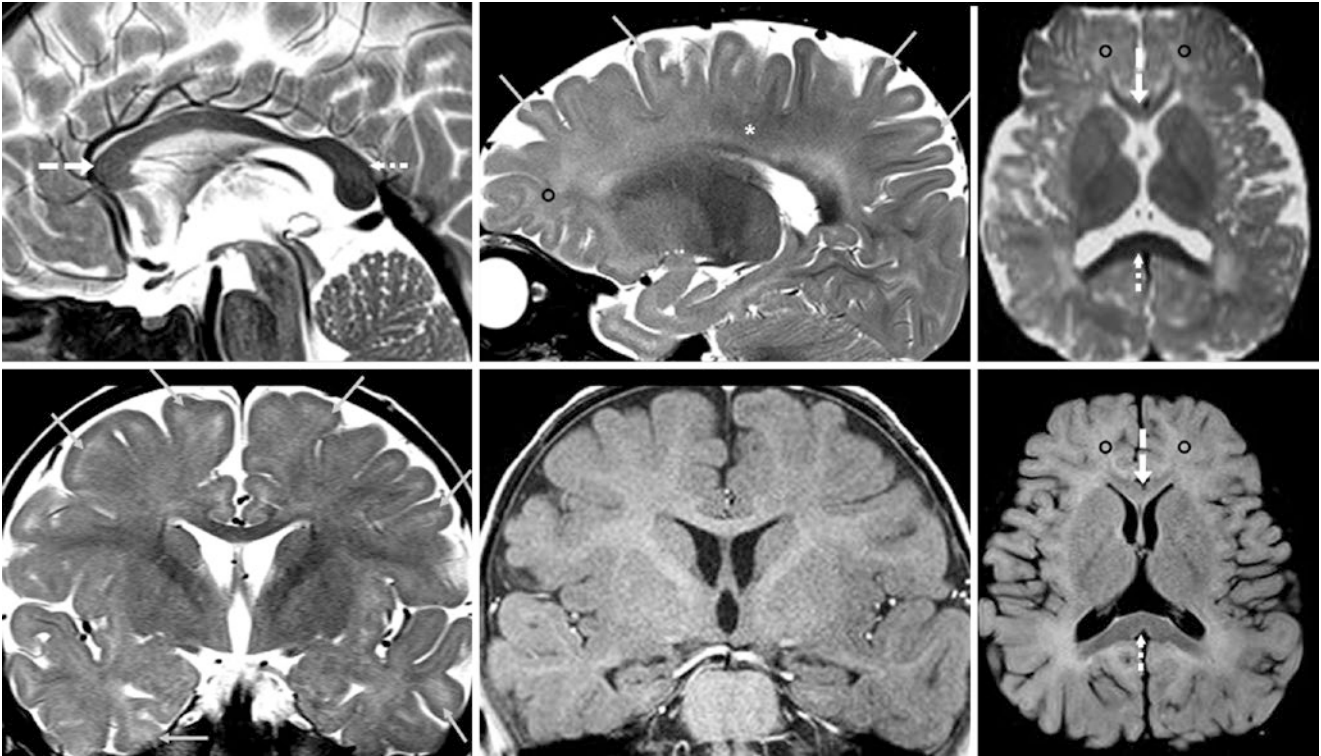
A 9.75-month-old with growth hormone deficit had a normal pituitary MRI at 3T. A sagittal SE T2WI (*top left*) shows a mature CS (*dotted arrow*); the CG (*dashed arrow*) is slightly less T2-dark. Further laterally, T2WI (*top middle*) depicts mature WM deep to the PRC (*asterisk*), but the OFWM (*circle*) is far less mature. This finding
